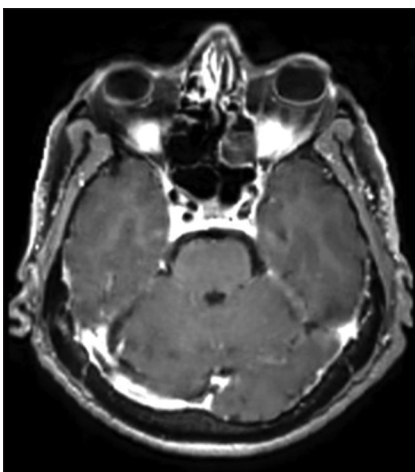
Suspicious post contrast sulcal FLAIR changes are noted involving cerebellar folia and occipital regions.
